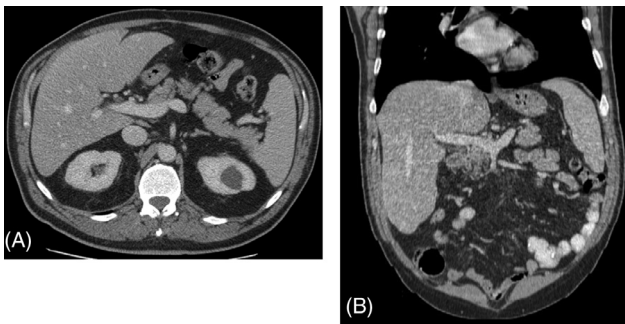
Follow-up contrast-enhanced computed tomography after 2 months. (A) Axial and (B) coronal images showing complete resolution of the thrombosis in the portal and superior mesenteric veins.
